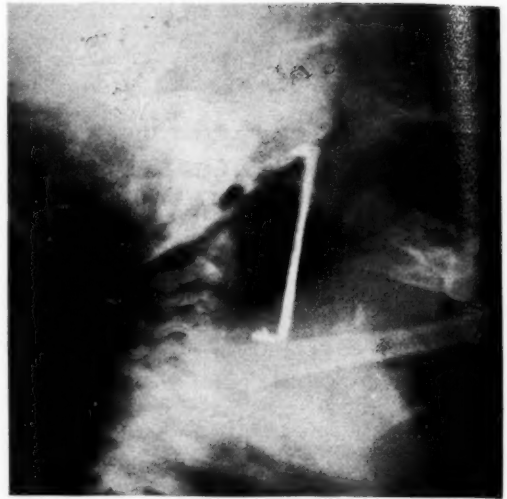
The roentgenogram made in the lateral position showing situation of the foreign body in the nasopharynx and esophagus.
